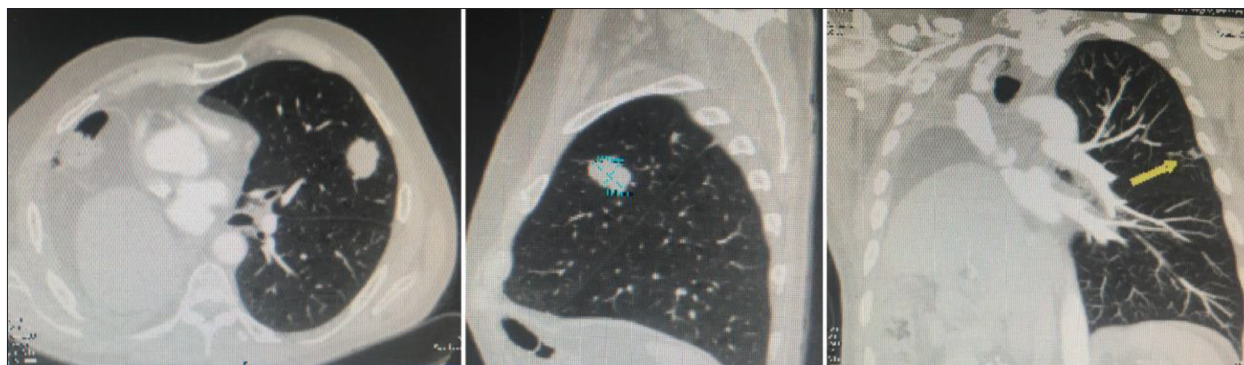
Multi-slice computed tomography finding of secondary deposits in the left lung
